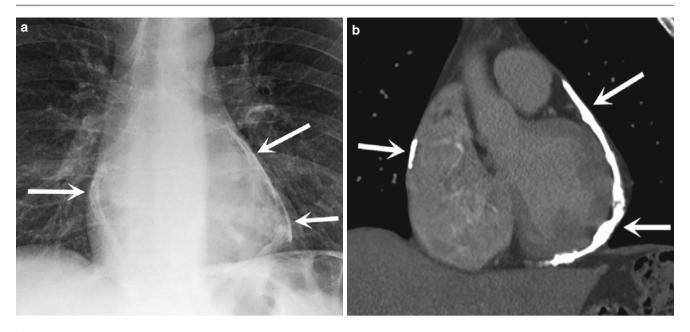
Frontal (a) radiograph and coronal CT (b) in a patient with constrictive pericarditis shows pencil-thin calcification (*arrows*) surrounding much of the pericardium
